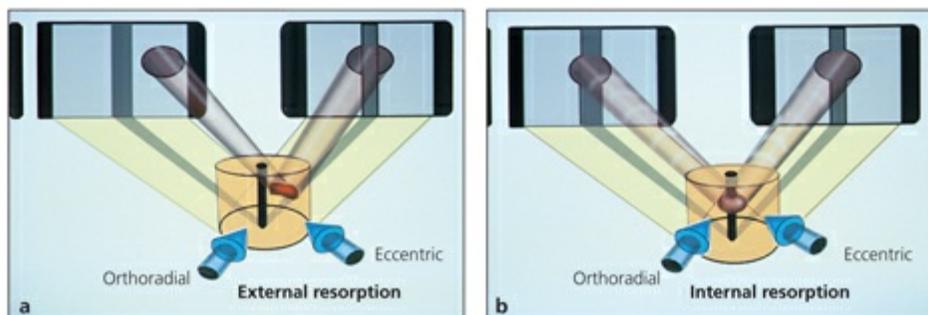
(*a and b*) Difference between appearances of external (*a*) and internal (*b*) root resorption when the radiographic angle is changed. (Courtesy of Dr Claudia Barthel, Düsseldorf, Germany.)
